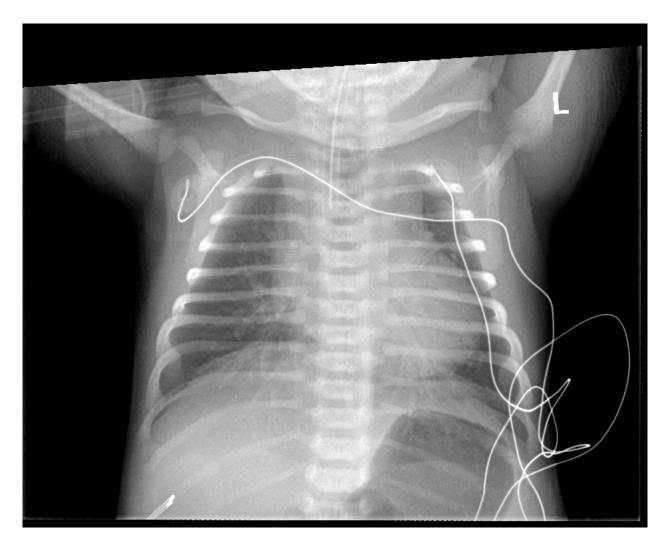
Image Source: Herman L. Intubated pediatric chest xray. Own work. 2022. Used with permission.
